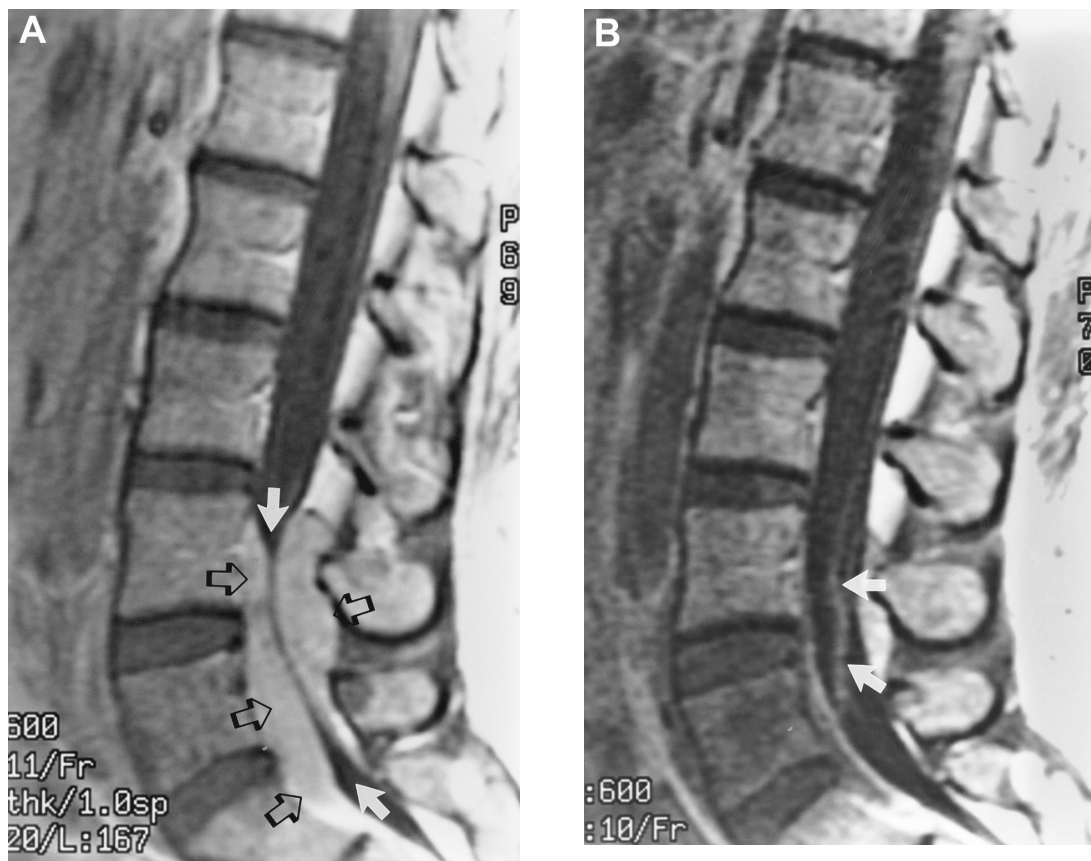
Hodgkin's disease of the lumbar spinal canal with epidural mass. (A,B) Post-contrast sagittal T₁-weighted images. (A) There is extensive ventral and dorsal epidural tumor (open arrows) squeezing the lumbar subarachnoid space and nerve roots (white arrows). (B) Post-radiation therapy follow-up MRI scan reveals near-complete disappearance of the epidural tumor with expansion of the lumbar subarachnoid space, which shows an excellent response to therapy. Some residual thickening of the nerve roots (arrows) is noted.
